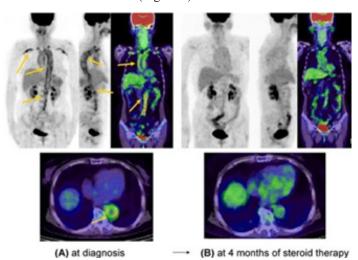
Large vessel vasculitis: 18F-fluorodeoxyglucose-positron emission tomography/computed tomography (FDG-PET/CT) images identifying (A) thoracic and abdominal aortitis and bilateral subclavian and subclavian arteritis; (B) Update went down markedly post corticosteroid therapy.
